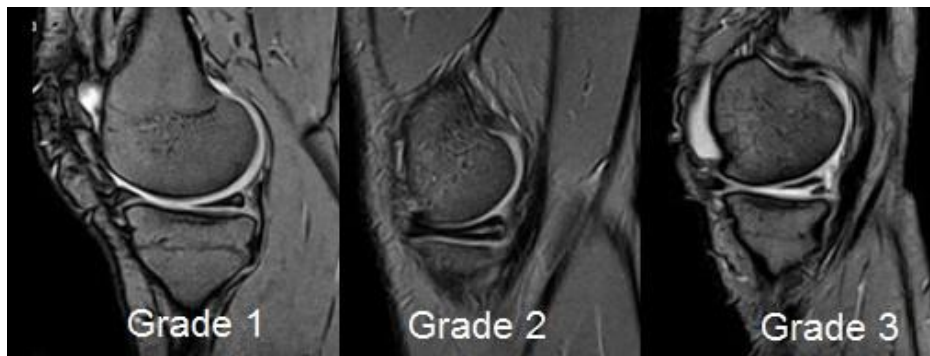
Sagittal MRI image shows grade1, 2 and 3 of the high signal in the posterior horn of the medial meniscus.
